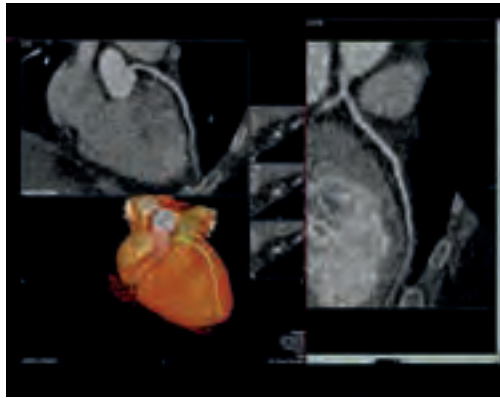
CT Coronary Angiogram. BMI 74. Normal coronaries. Dose 4.8 mSv
